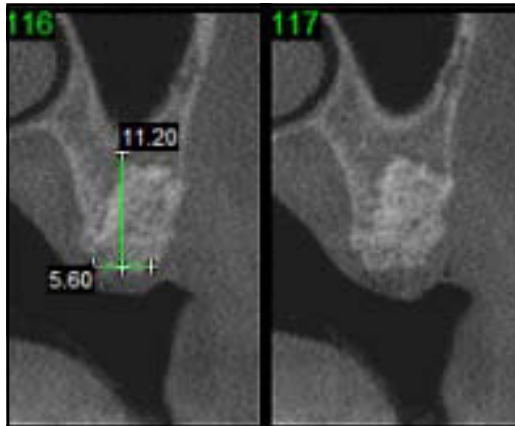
CT scan evaluation at 6 months demonstrating the possibility of radiographic reconstruction of the ridge at the biopsy site.
